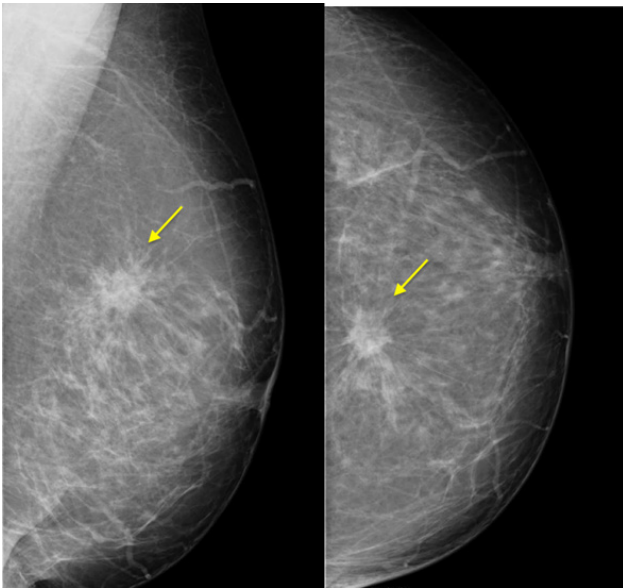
Woman with a history of implants removal due to complication. The mammographic study revealed the presence of a suspicious lesion, with spiculated contours, and the biopsy result was negative. The MRI study revealed the presence of a non-capturing lesion, with a positive sign for silicone.
